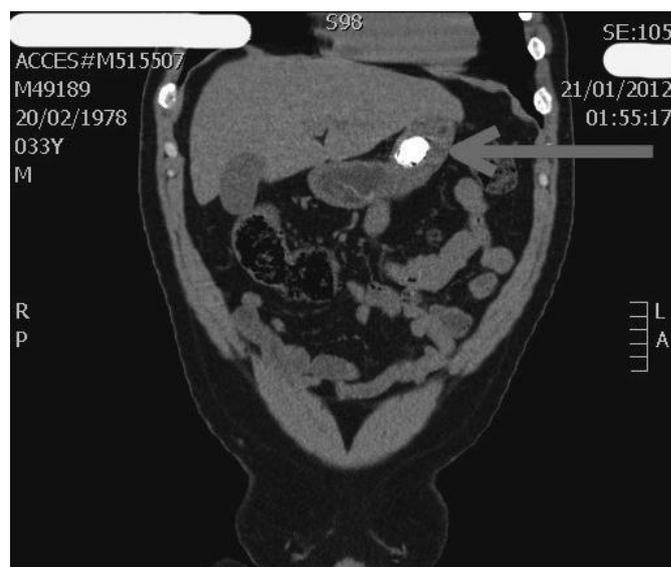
Gastric foreign body, CT scan coronal reconstruction.
